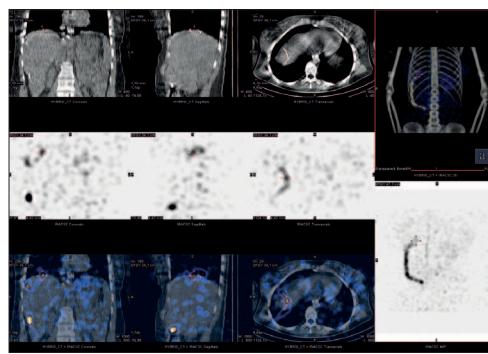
The 4-hour SPECT/CT images of the abdomen revealed that the distal tip of the shunt migrated into the subphrenic space.
